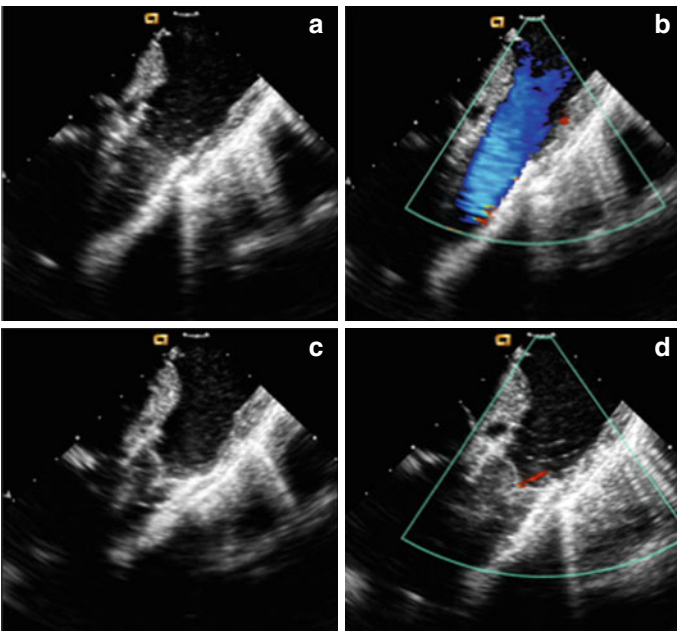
Intracardiac echocardiography. (a) At baseline color Doppler demonstrates free pulmonic regurgitation and narrowed valve. (b) Continuous wave Doppler across the RVOT at baseline showing significant gradient. (c) After presenting the RVOT, (d) color Doppler demonstrates wide open pulmonic insufficiency. (e) After Melody valve implantation, (f) color Doppler demonstrates no residual insufficiency
